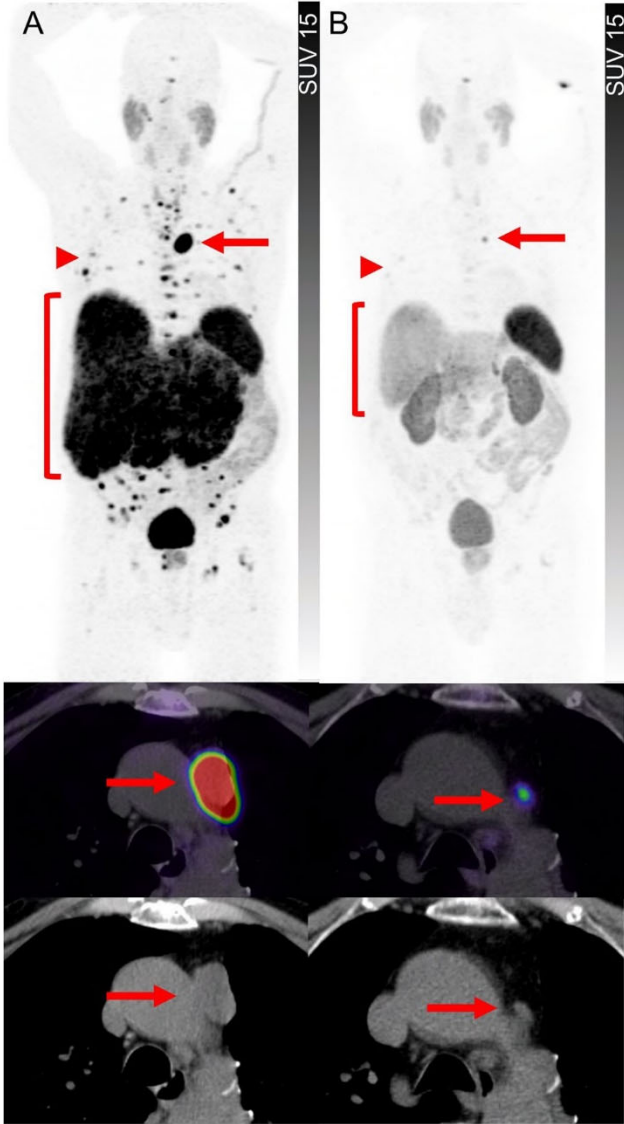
A representative patient with metastatic atypical lung carcinoid with partial response on ^{68}Ga -DOTATATE PET/CT and CT at 3 months post PRRT. Maximum intensity projection PET, PET/CT and CT at baseline (A) and three months follow-up (B) show marked response to treatment in the liver (brackets), bones (arrowheads) and lymph nodes (arrows)
